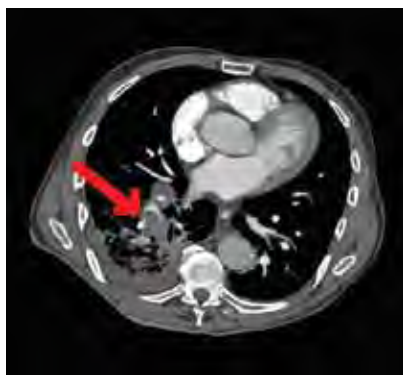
CT scan of the thorax showing pulmonary emboli.
